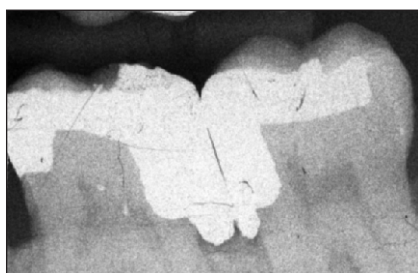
Preoperative radiographic image of teeth #30 and #31. Deep gingival overhang existed in both the distal portion of #30 and the mesial portion of #31.
